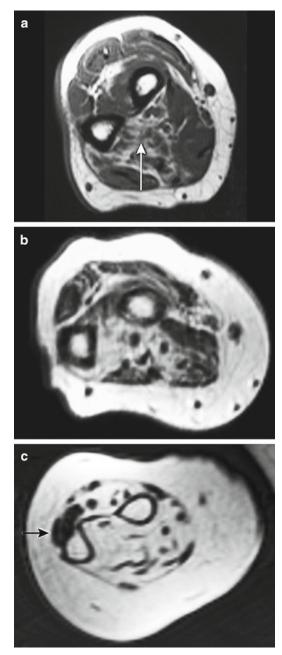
Axial T1-weighted magnetic resonance imaging (MRI) scans of the right forearms of patients with inclusion body myositis. (a) Mild and isolated fatty infiltration of the deep finger flexor (*white arrow*). (b) Moderate fatty infiltration of the flexors (especially the deep finger flexors), in contrast to the less severely infiltrated extensor compartment. (c) Severely fatty infiltrated muscles, with relative sparing of the extensor carpi ulnaris (*black arrow*) muscle
